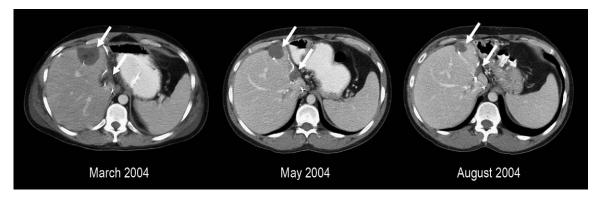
Portal venous phase CT scans of the first patient, taken from consecutive series of triphasic CT scans performed between March and August 2004. *White arrows* point to resected areas in segment IV that are filling in due to liver regeneration. Persistent metastatic disease is seen around the RHV in segments VII/VIII.
